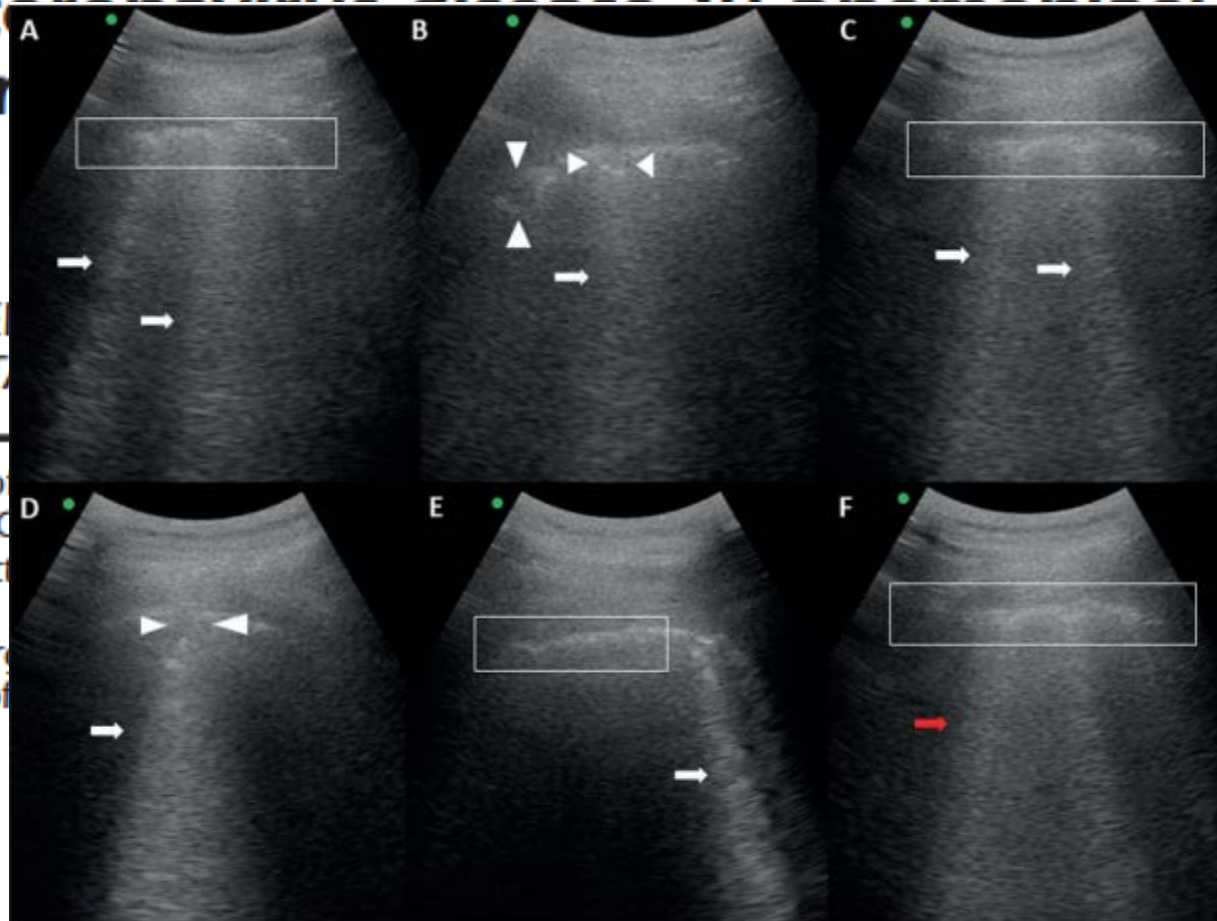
Lung ultrasound findings in a patient with confirmed nCoV-19 infection. Lung ultrasound shows pleural line irregularities (within the white boxes, figures A-C-E-F), thick irregular vertical artifacts (white arrows, figures A-B-C-D-E), subpleural consolidations (white arrowheads, figure B-D) and areas of white lung (red arrow, figure F).
